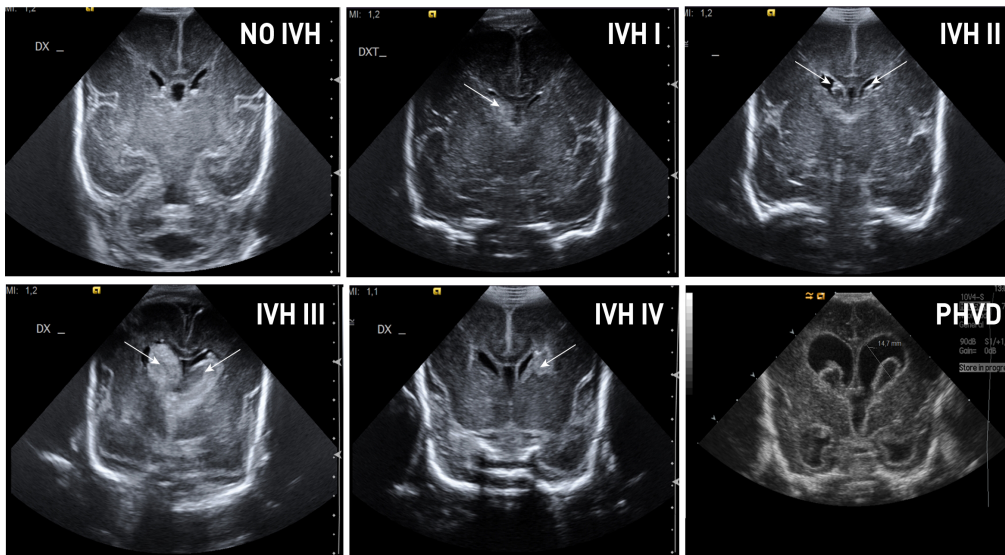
Cranial ultrasound from preterm infants.
